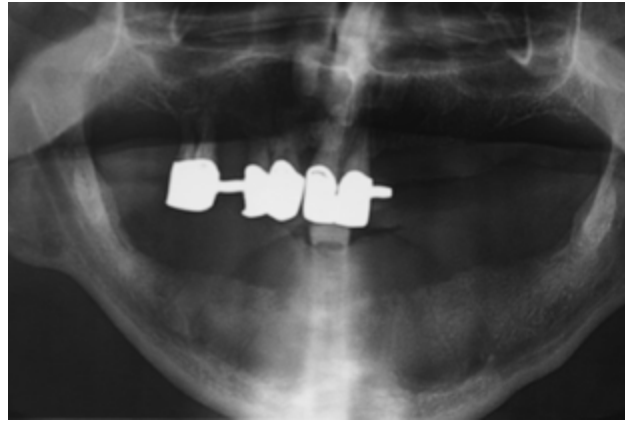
Case B, initial panoramic radiography of the patient.
